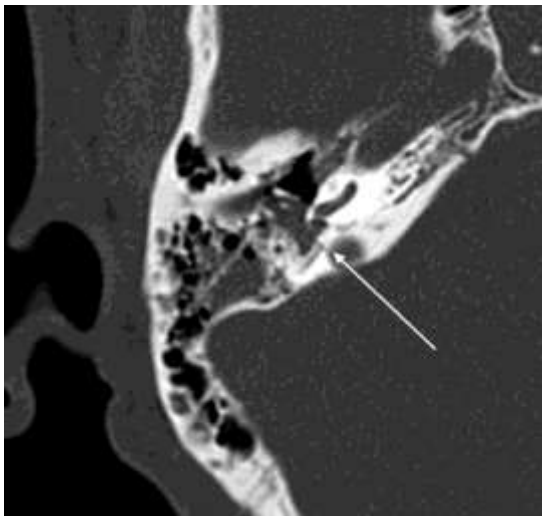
Transverse temporal bone fracture; axial MDCT scan (head trauma spiral CT protocol with 1mm thick slices) shows a transverse fracture line involving the right superior semicircular canal (arrow).
